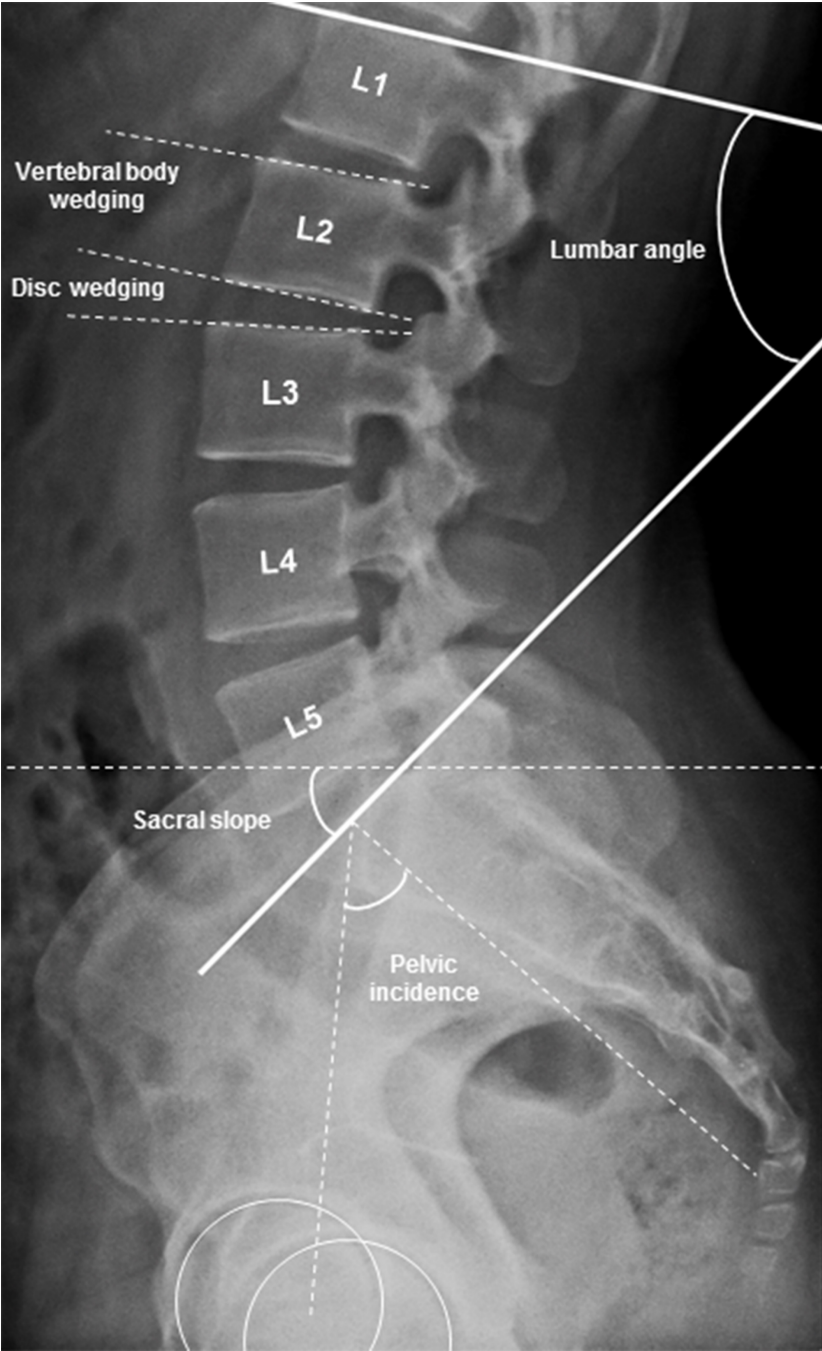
Radiographic measurements
